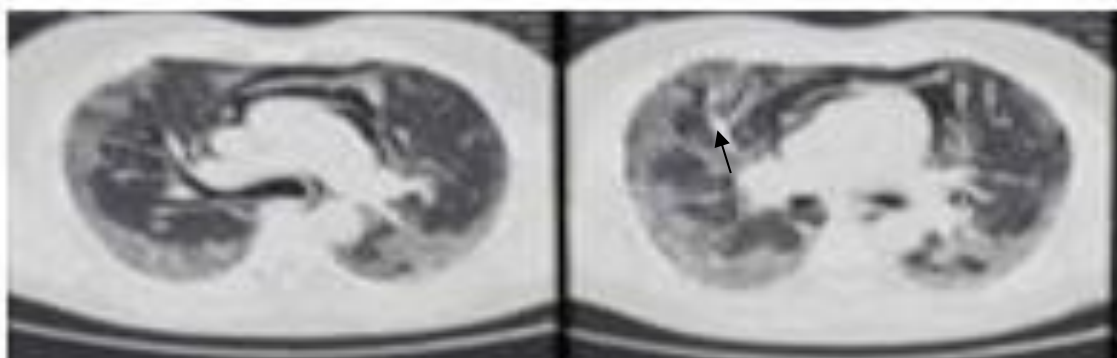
CT of abdomen and chest showing: CT chest showing ground glass opacity and peripheral alveolar opacity and fibrosis bands.
